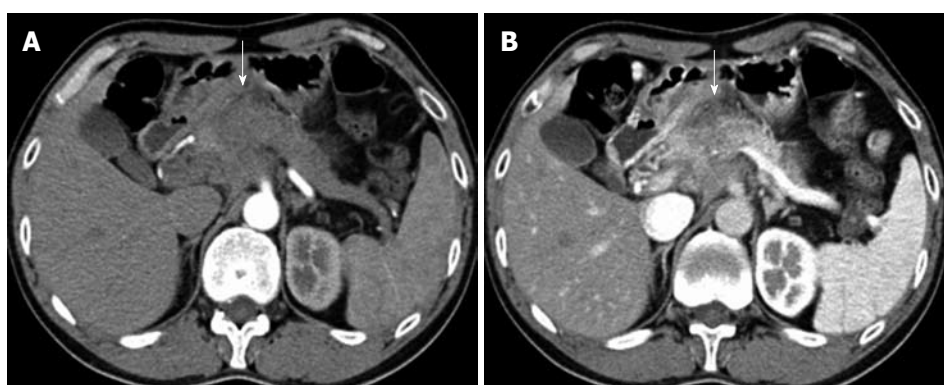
Abdominal contrast-enhanced multi-detector computed tomography scan. A: A mass in the neck of pancreas (arrow) is shown in arterial phase; B: The mass in venous phase.
